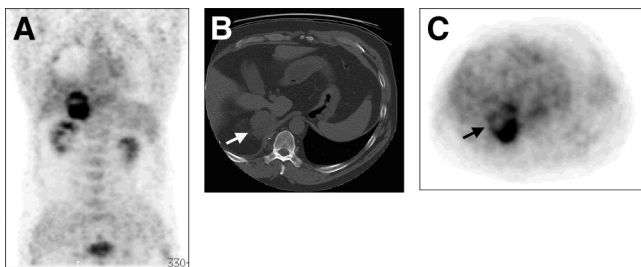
(A) ^{18}F -FDG PET scan shows intense uptake in right adrenal mass, with central photopenic area. (B) CT scan shows large right adrenal mass with central lower-attenuation area indicating central necrosis (arrow). (C) ^{18}F -FDG PET axial view at same level as for CT shows intense uptake in right adrenal mass, with central photopenic area indicating central necrosis (arrow).
